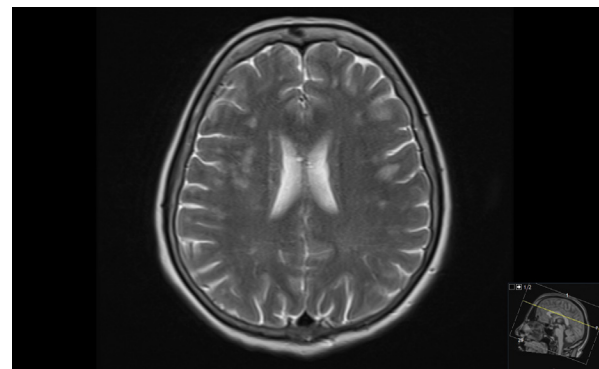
Axial FLAIR weighted MRI of a SLE patient. (the same patient). The periventricular hyperintensity of SLE patient.
